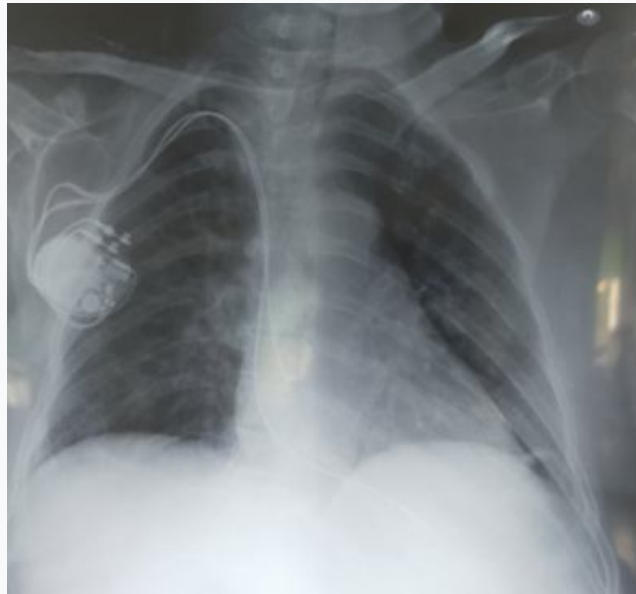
chest X-ray of the first patient after pace maker implantation
